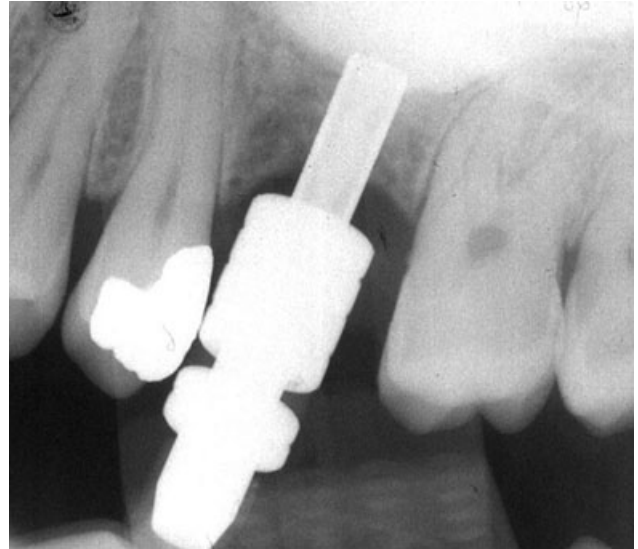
Periapical radiograph of balloon harboring device during inflation.
